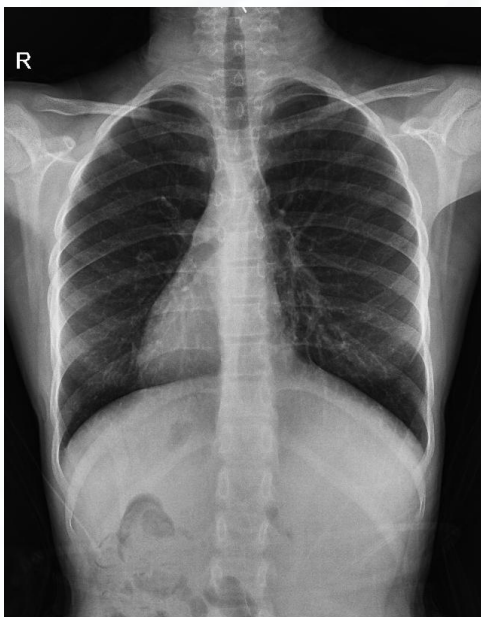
Chest radiography shows dextrocardia.
